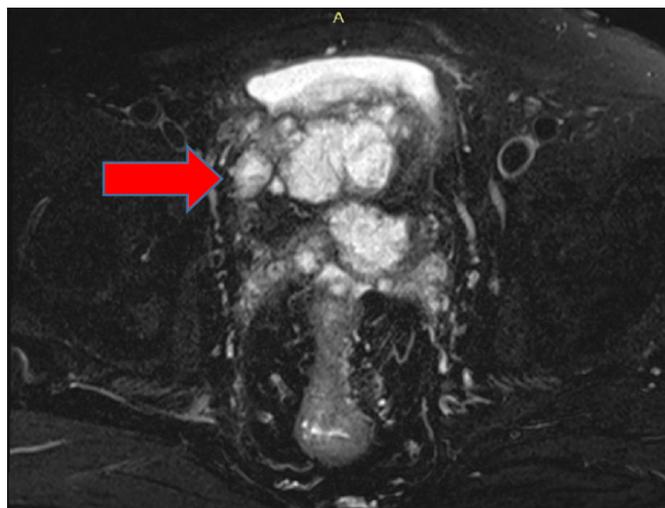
T2 fat suppression pelvic MRI (arrow pointing towards the tumor, invading the urinary bladder and prostate) – coronal view
